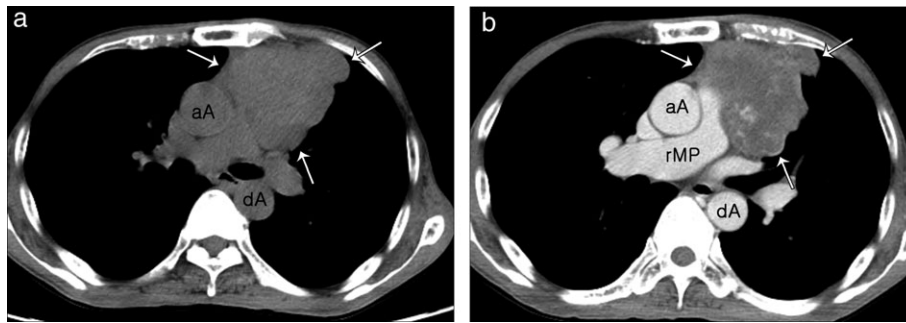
(a) Unenhanced and (b) contrast-enhanced images of initial chest computed tomography. There is a 9 × 7 cm mass (arrows, a,b) in the anterior mediastinum, which had a lobular margin and showed heterogeneous enhancement without a demonstrable fat component, with extrinsic compression and/or early invasion of adjacent mediastinal great vessels and left upper lobe. aA, ascending thoracic aorta; dA, descending thoracic aorta; rMP, right main pulmonary artery.
